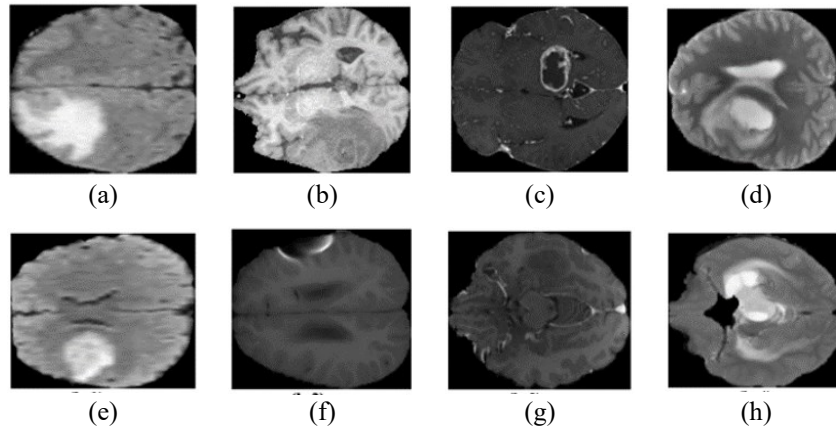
Brain tumor MRI images of the two classes with multi-modality: (a) HGG-Flair, (b) HGG-T1, (c) HGG-T1ce, (d) HGG-T2, (e) LGG-Flair, (f) LGG-T1, (g) LGG-T1ce, and (h) LGG-T2
